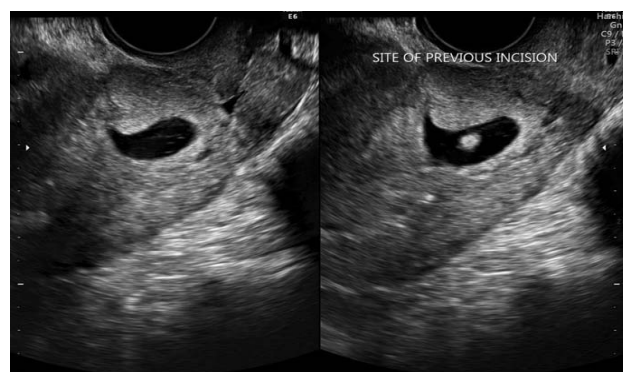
(Case 2) Transvaginal ultrasound transverse view showing gestational sac at the site of prior scar
